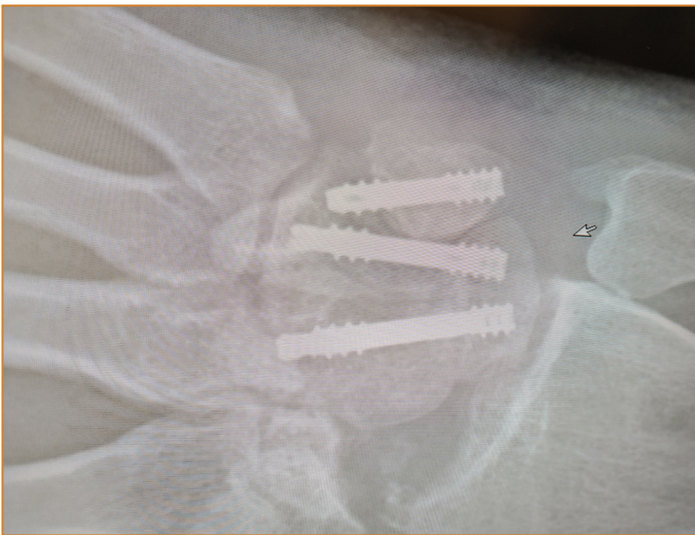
Posterior anterior radiograph at 3 months demonstrating good bony consolidation at the fusion site.
